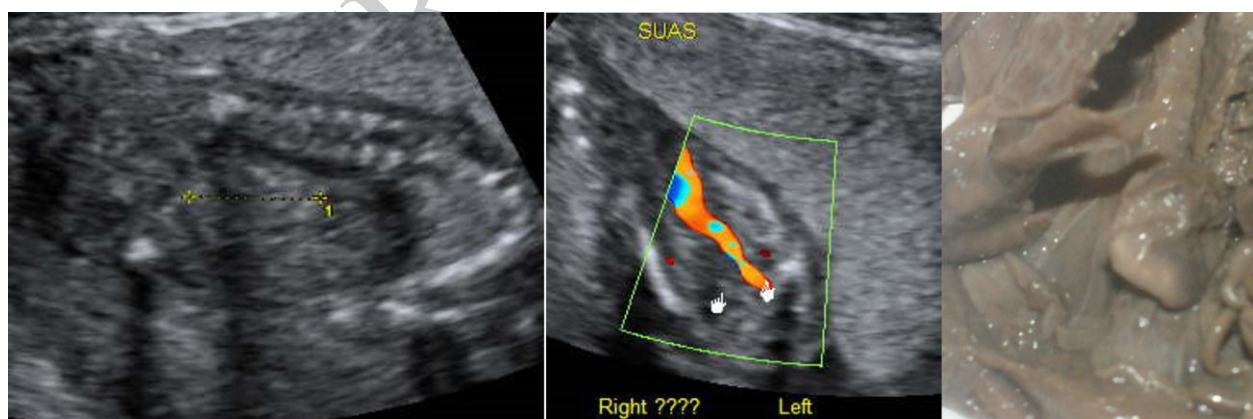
Case 5, ultrasound (kidney and paravesical absent right artery), and macroscopic pathological aspect.
